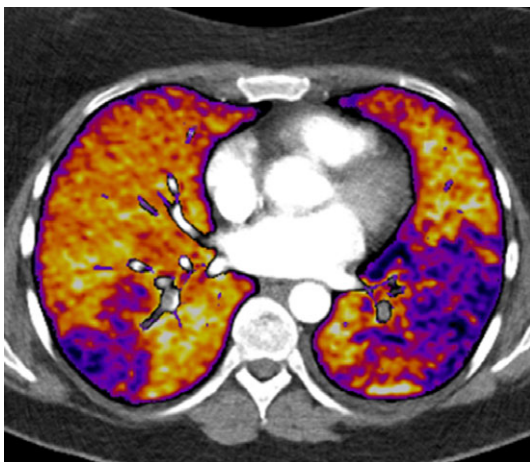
3 mm axial reconstruction of CT pulmonary angiography (CTPA) with an iodine map created with subtraction CT, with a 100 kV CTPA image as underlay. The image displays wedge-shaped perfusion defects caused by bilateral pulmonary emboli. [Color figure can be viewed at [wileyonlinelibrary.com](http://wileyonlinelibrary.com)]
